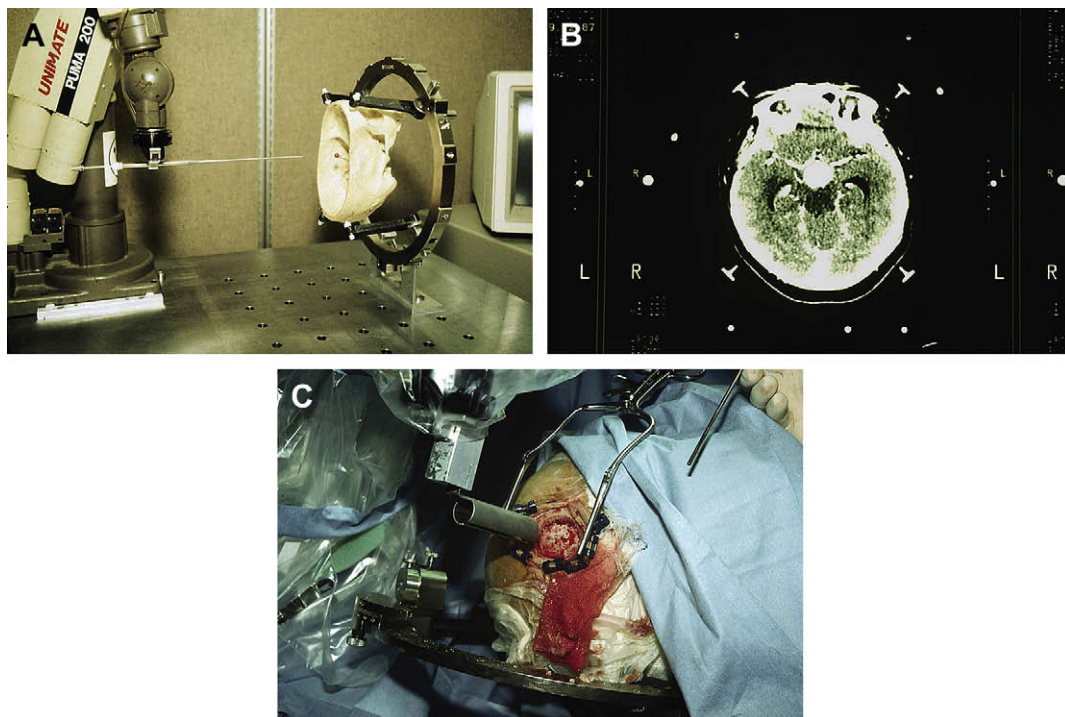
The PUMA 200 is a six-DOF manipulator capable of moving at a peak velocity of 1 m/s while carrying a payload of 1 kg. (A) The PUMA 200 arm directs a probe towards the planned target in a skull. (B) A preoperative CT scan taken with the Brown-Roberts-Wells stereotactic frame shows a thalamic astrocytoma. Stereotactic coordinates are calculated from the preoperative imaging. (C) The PUMA arm, gripping a retractor, moves into position in the surgical field. (Courtesy of James Drake, MD, University of Toronto, Canada.)
